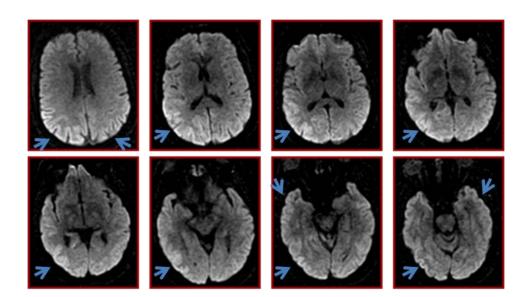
DWI obtained 3 weeks after symptom onset, showing restricted diffusion in the parietal and occipital cortex, the cortical ribbon sign (blue arrows). Corresponding FLAIR and T2 images did not show changes.
